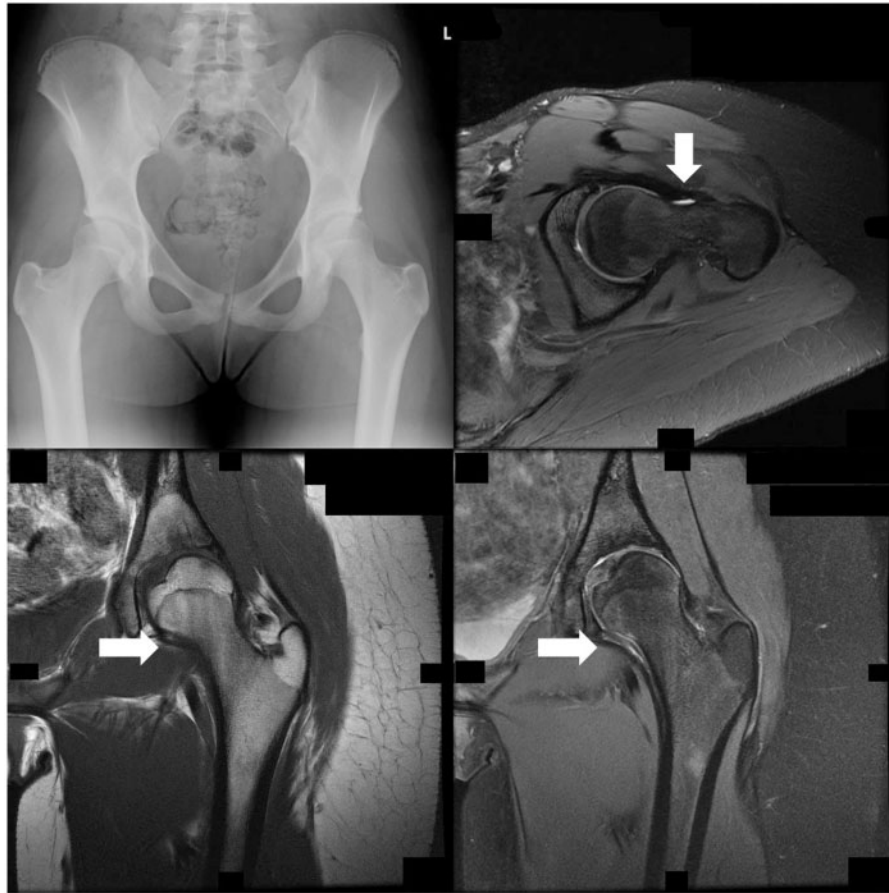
X-ray and MRI scan. Arrow shows the area with abnormal intensity, which was consistent with the cyst found on the medial synovial fold.
